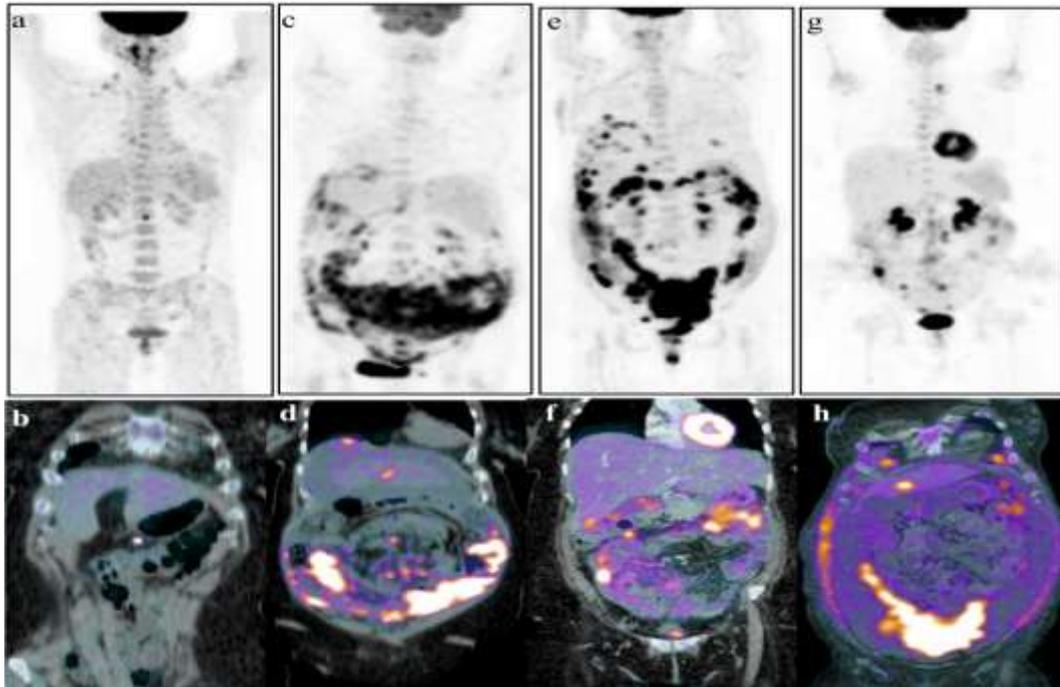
Images for different patterns of peritoneal metastases. PET MIP and Coronal Views for fused PET/CT. Single nodule (a and b), diffuse (c and d), multiple nodules (e and F) and mixed pattern (g and h).
